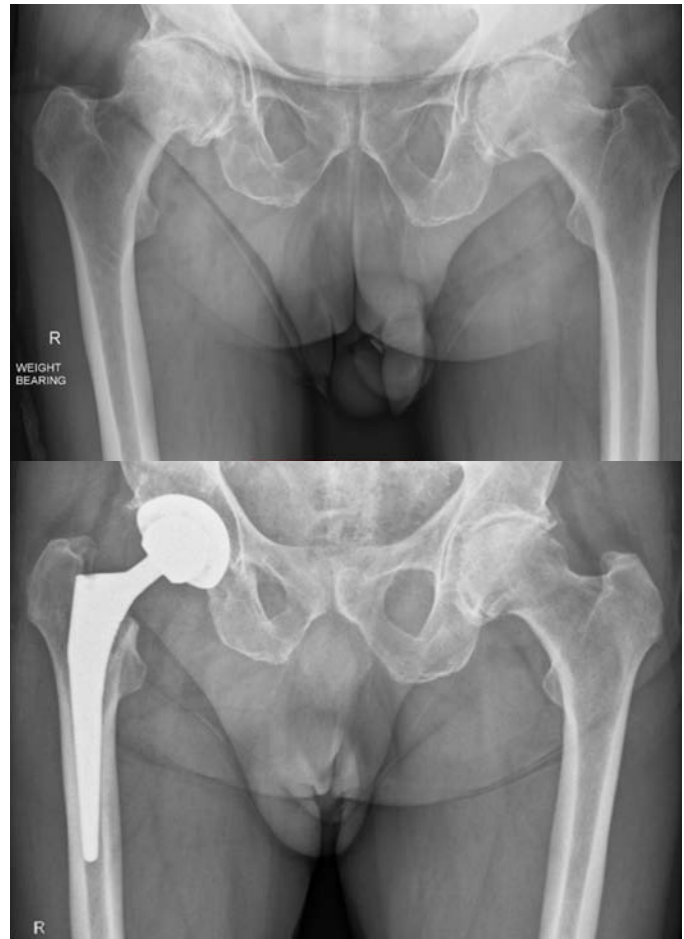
Preoperative and postoperative radiographs.
